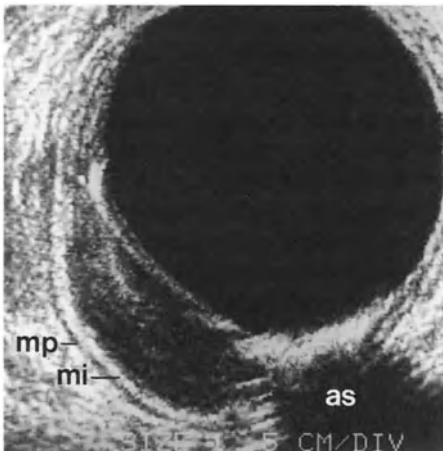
Sonogram of adenoma (*a*). The muscularis propria (*mp*) is demonstrated between the middle (*mi*) and outer (*oi*) interfaces
